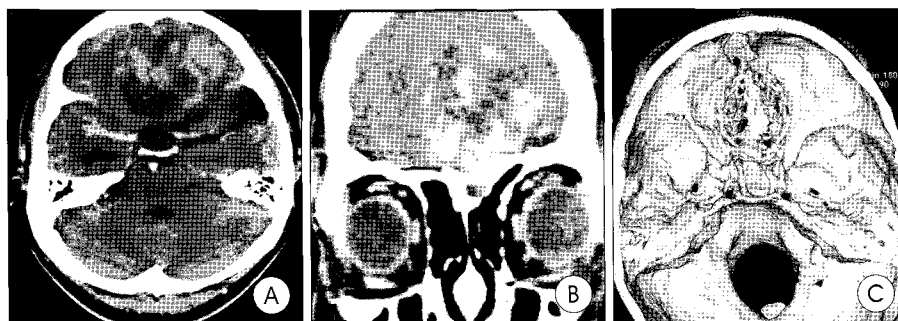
A : Brain axial computed tomography (CT) scan shows a large frontal mass with a relatively irregular contour and with heterogeneous enhancement. B : Contrast enhanced coronal CT scan shows a mass localized on the left cribriform plate which is displaced downward and eroded. C : Three-dimensional CT scan of skull base shows the erosion and depression of the left cribriform plate.
